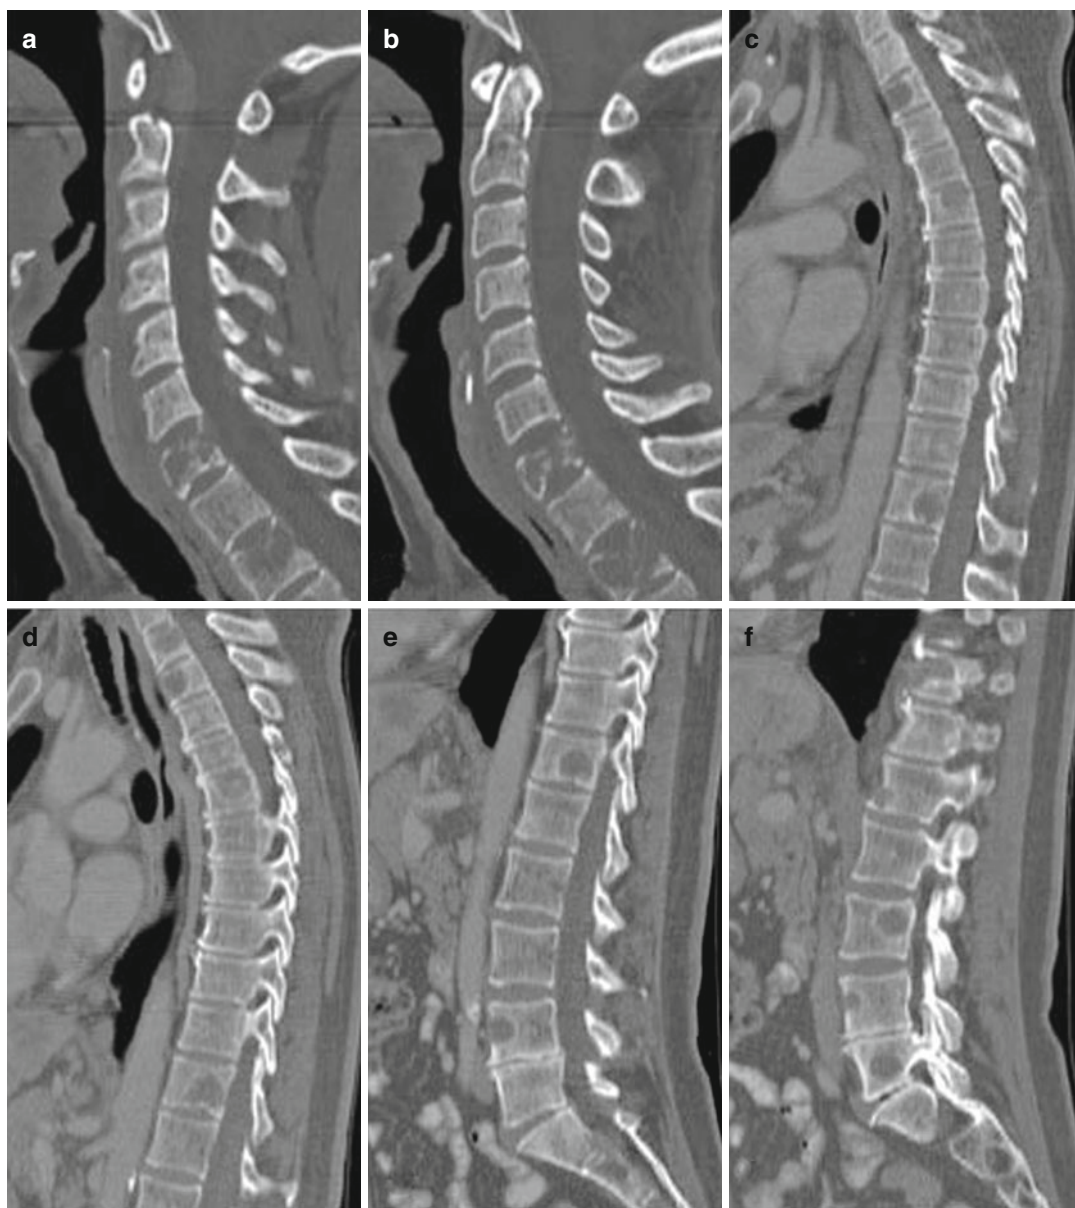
Multiple spine metastases from lung carcinoma: sagittal CT reformatted (a–f). MRI scan: STIR (g, j), T1W FSE (h, i), T1W FSE with intravenous gadolinium contrast medium (k, l)
